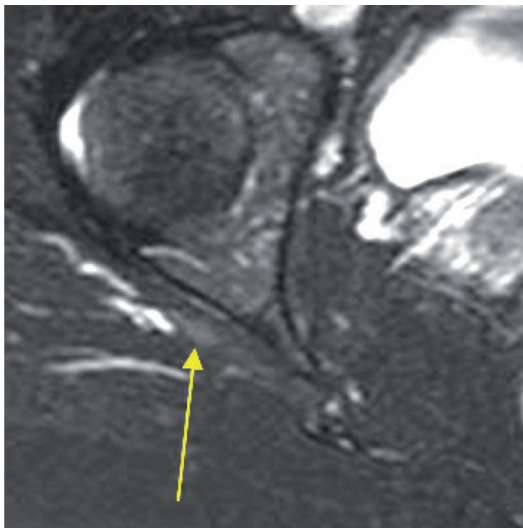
Axial STIR MR image showing the close relationship of the sciatic nerve (arrow) with prominent hyperintense vessels: note that the flowing blood vessels are seen as the brightest structures in the image making the detection of nerve somewhat difficult.
